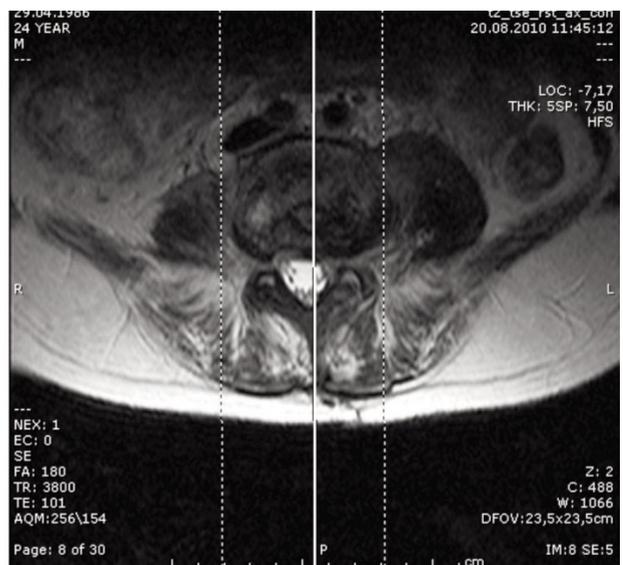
X-ray and MRI images in the postoperative fifth month.
